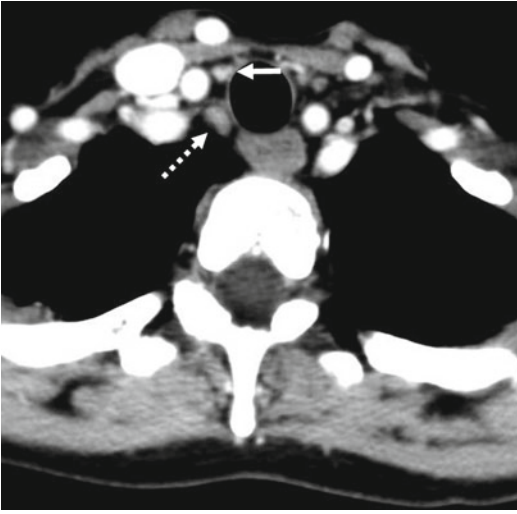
Transverse contrast-enhanced CT image demonstrating the typical difference in contrast enhancement between a parathyroid adenoma (*solid arrow*) and a lymph node (*dashed arrow*), both in the right paratracheal region. Parathyroid adenomas typically enhance earlier and more intensely than lymph nodes
